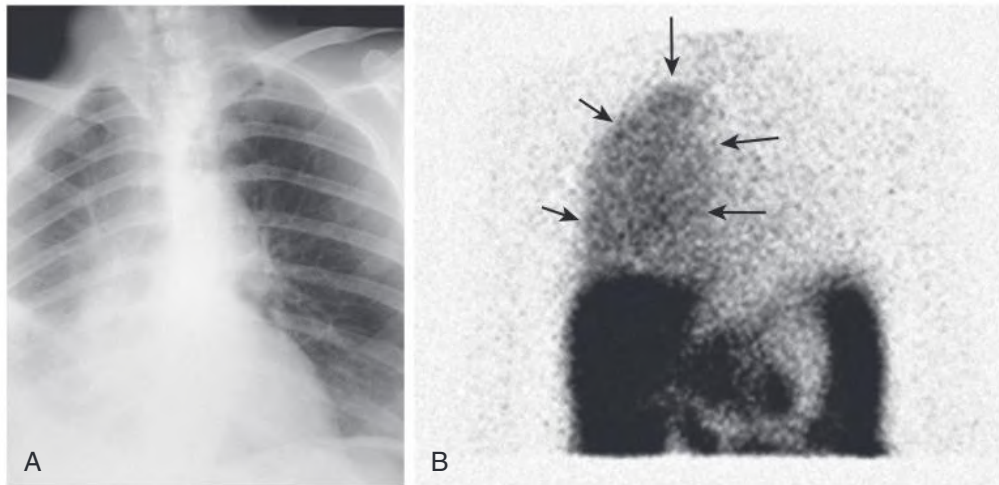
Hydrothorax in Peritoneal Dialysis. (A) Chest radiograph showing a right-sided pleural effusion with partial collapse of the right lung caused by a diaphragmatic leak. (B) Scintigram in a peritoneal dialysis patient showing isotope in the right hemithorax (arrows) confirming a right pleural effusion.
